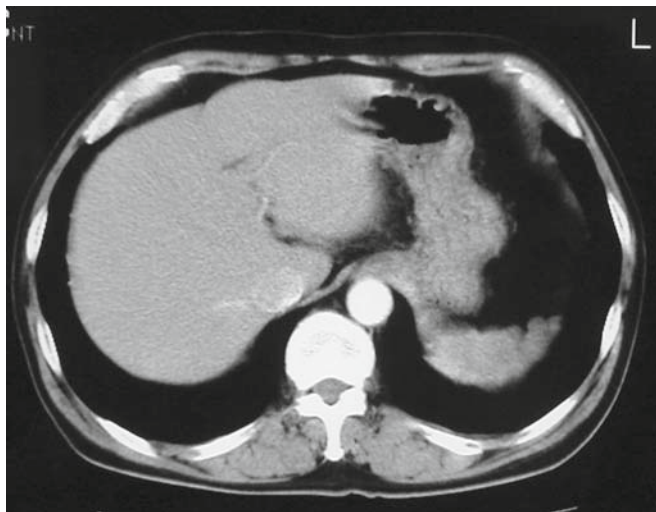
Preoperative enhanced computed tomography (CT). No focal lesions can be detected in the liver
